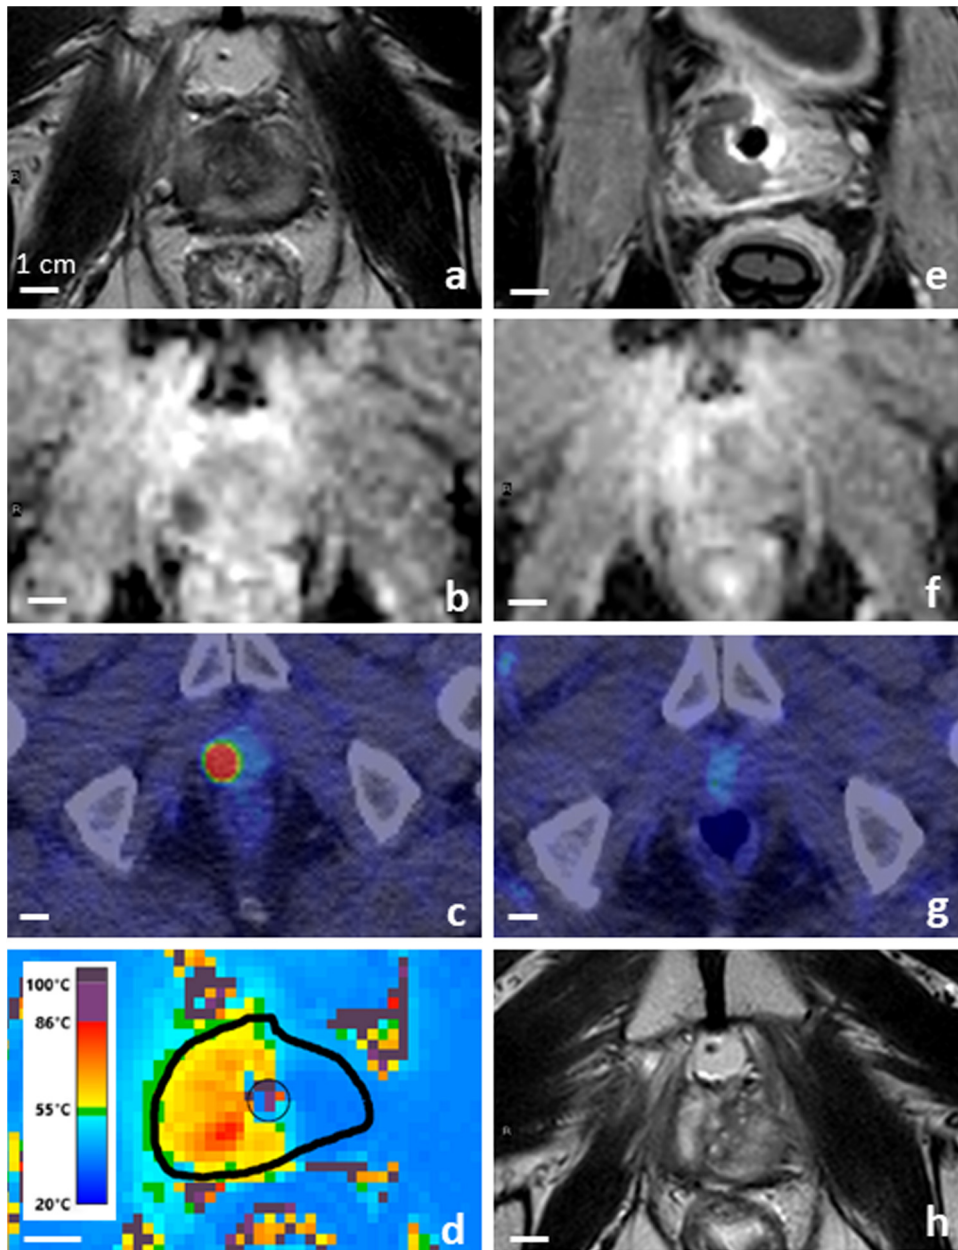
Example of a patient case. (A,B) Screening T2-weighted and diffusion-weighted MRI revealed a distinct focus graded as a Likert 5 lesion, which was also present on (C) ^{18}F -PSMA-1007 PET-CT (maximum standardized uptake value 44.6) (c). The patient underwent (D) targeted hemiablation, during which the targeted prostate region reached a lethal minimum temperature of 55 °C. (E) The nonperfused volume can be visualized immediately after treatment, which demonstrates the acute ablation effect. At 12 mo the patient underwent additional follow-up imaging. (F,H) Multiparametric MRI and (G) ^{18}F -PSMA-1007 PET-CT were both negative. The prostate volume decreased from 18 to 10 cm³ (56%) at 12 mo. The imaging findings agree with a post-sTULSA biopsy, which showed no vital cancer. MRI = magnetic resonance imaging; PSMA-1007 = prostate-specific membrane antigen ligand 1007; PET = positron emission tomography; CT = computed tomography; sTULSA = salvage MRI-guided transurethral ultrasound ablation.
